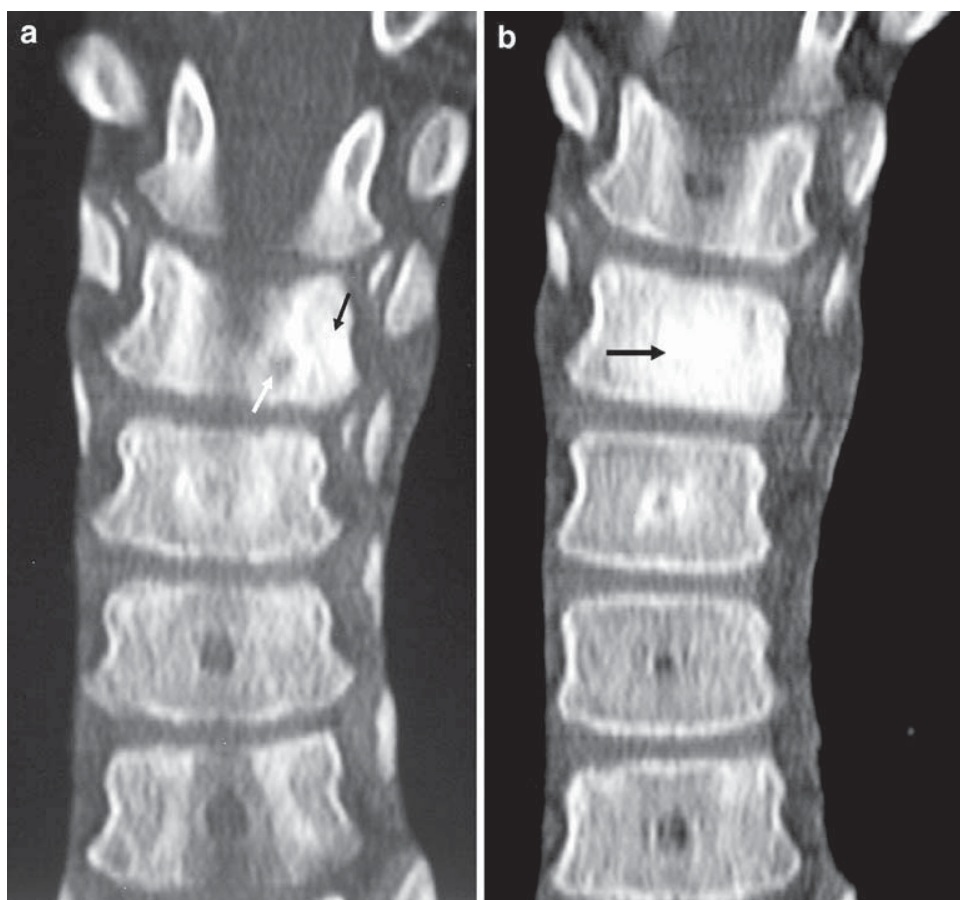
a CT: eight months post initial presentation. b CT with contrast: eight months post initial presentation
